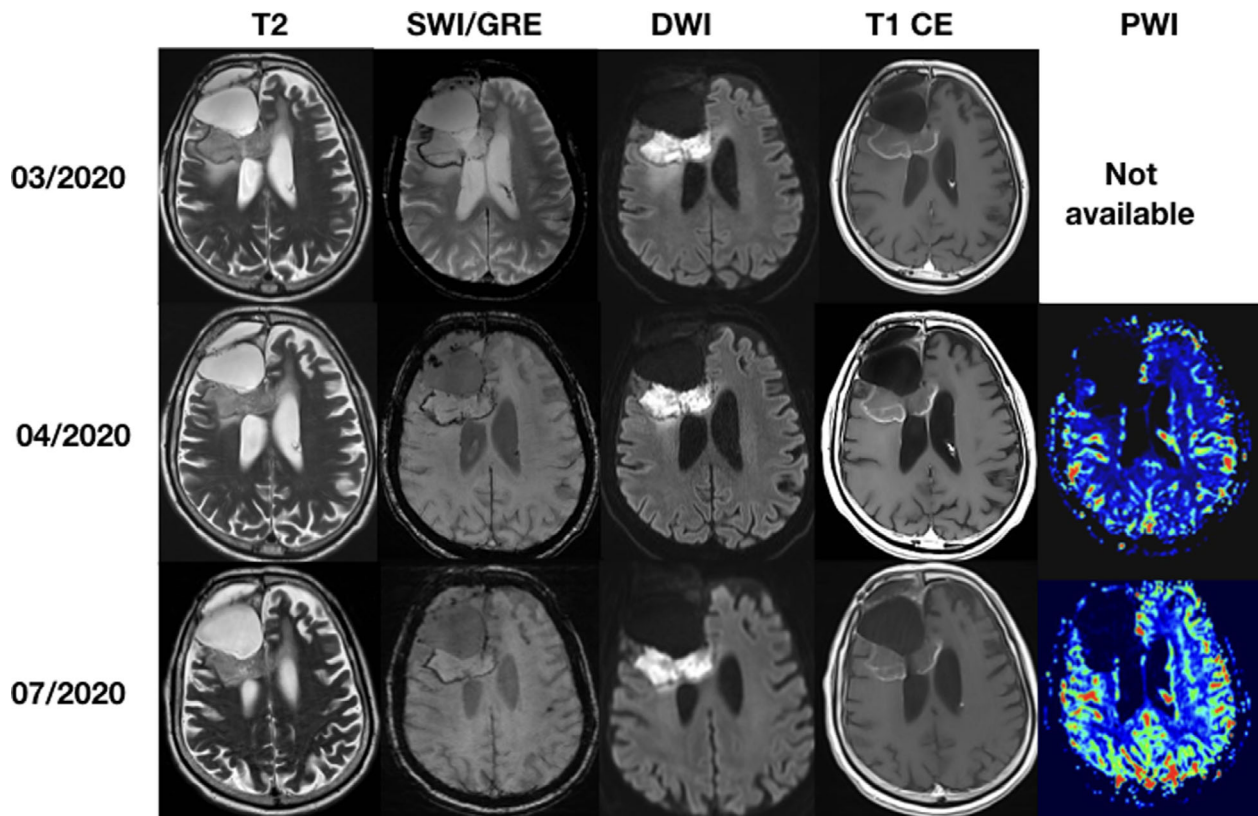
MRI examinations after 1 (first row), 2 (second row) and 5 months (third row) showing progressive reduction of oedema and SWI-T2 hypointensity (first and second column), more regular linear contrast enhancement (CE) (fourth column) and persistent DWI restriction (third column). PWI (fifth column) showed persistent low rCBV values.
